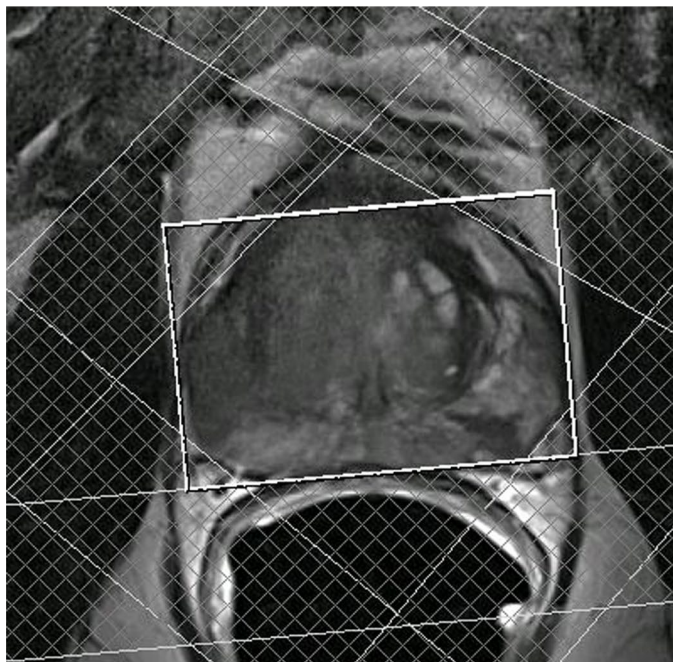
T2-weighted image of the prostate of a 54-year-old man with biopsy-proven prostate cancer. The white box indicates the volume of interest and outer volume saturation slabs for lipid suppression surround the prostate.*
